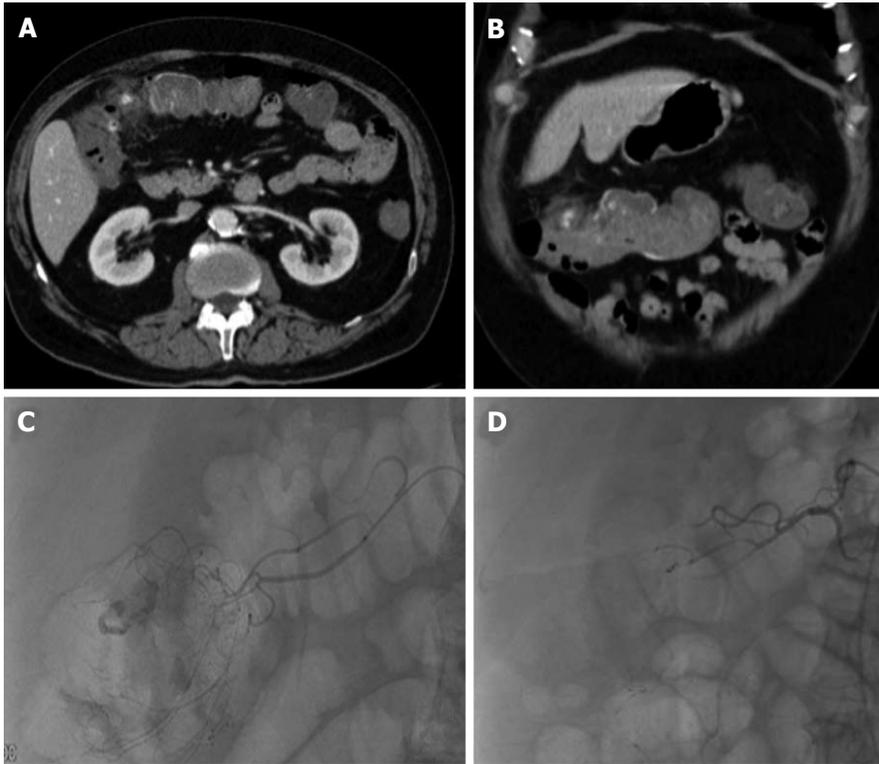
Lower gastrointestinal bleed from acute diverticulitis. Seventy-three-year-old male patient with bloody diarrhea, severely hypotensive (blood pressure 70/40) requiring 10 units of packed red blood cells. A and B: Contrast enhanced computed tomography abdomen demonstrates acute diverticulitis at the hepatic flexure, with active hemorrhage; C: Visceral angiography demonstrates the region of active bleeding in the ascending colon at the hepatic flexure; D: Successful distal Gelfoam and coil embolization of the supplying right colic artery branches.
